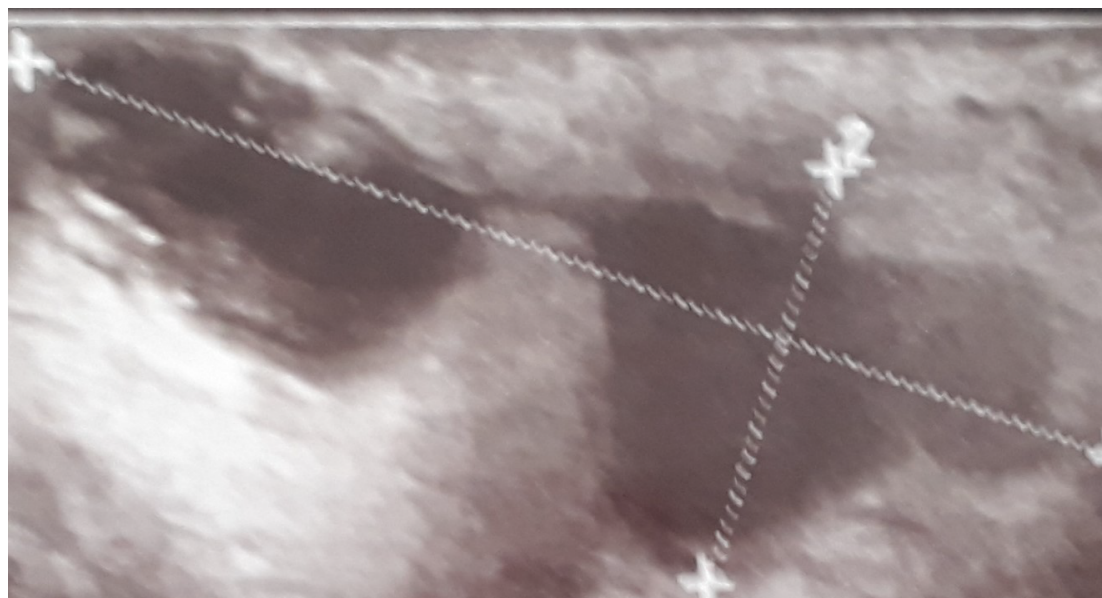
Inguinal abscess with septations on ultrasound.
